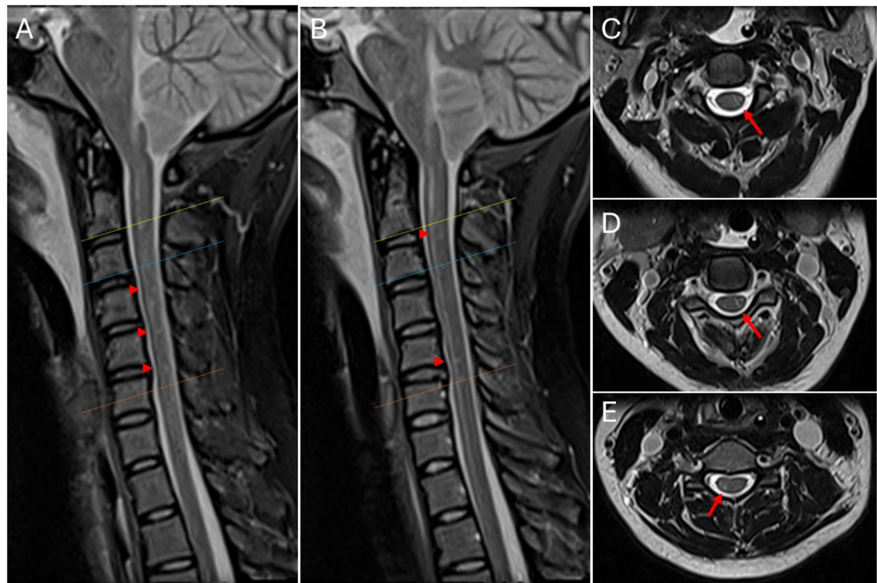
Patchy T2 hyperintensities in the cervical spine on MRI. (A) and (B), Sagittal T2 STIR sequences in different sagittal planes show patchy areas of T2 hyperintensities (arrowheads). (C)-(E), Axial T2 sequences at the levels of the yellow (C), blue (D), and orange (E) dotted lines show areas of T2 hyperintensities (arrows).
